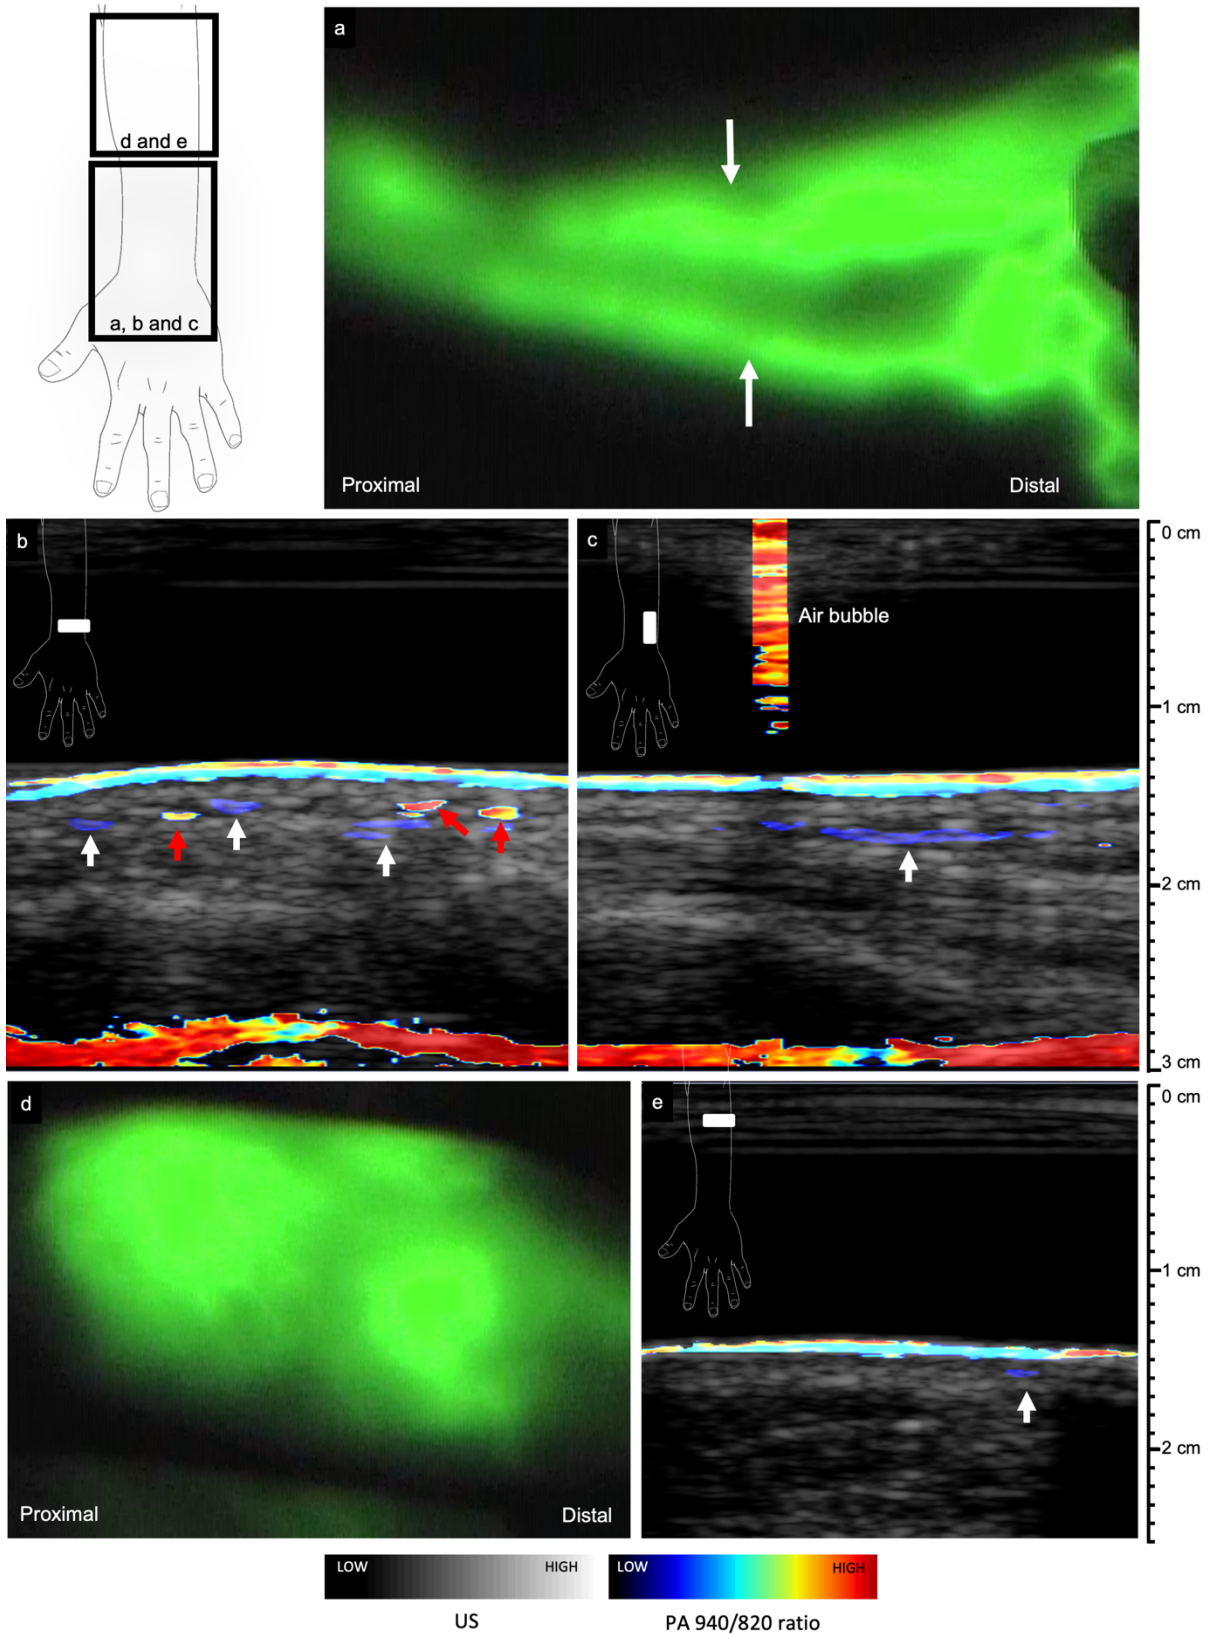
Near infrared fluorescence lymphography (NIRF-L) and 940/820 nm ratio photoacoustic (PA) and ultrasound images of a lymphedema arm (patient 1). White arrows indicate lymphatic vessels and red arrows indicate blood vessels. (a) NIRF-L image of the dorsal wrist showing two patent lymphatic vessels (linear pattern). (b) Axial PA image slice of the dorsal wrist. Multiple lymphatic vessels (dark blue) and veins (dark red) are visible. (c) Parallel PA image slice of the dorsal wrist. A lymphatic vessel (dark blue) is clearly visible. (d) NIRF-L image of the dorsal forearm showing dermal backflow. (e) Axial PAI image slice of the dorsal forearm at a location with DBF observed with NIRF-L. A lymphatic vessel is visible (white arrow).
